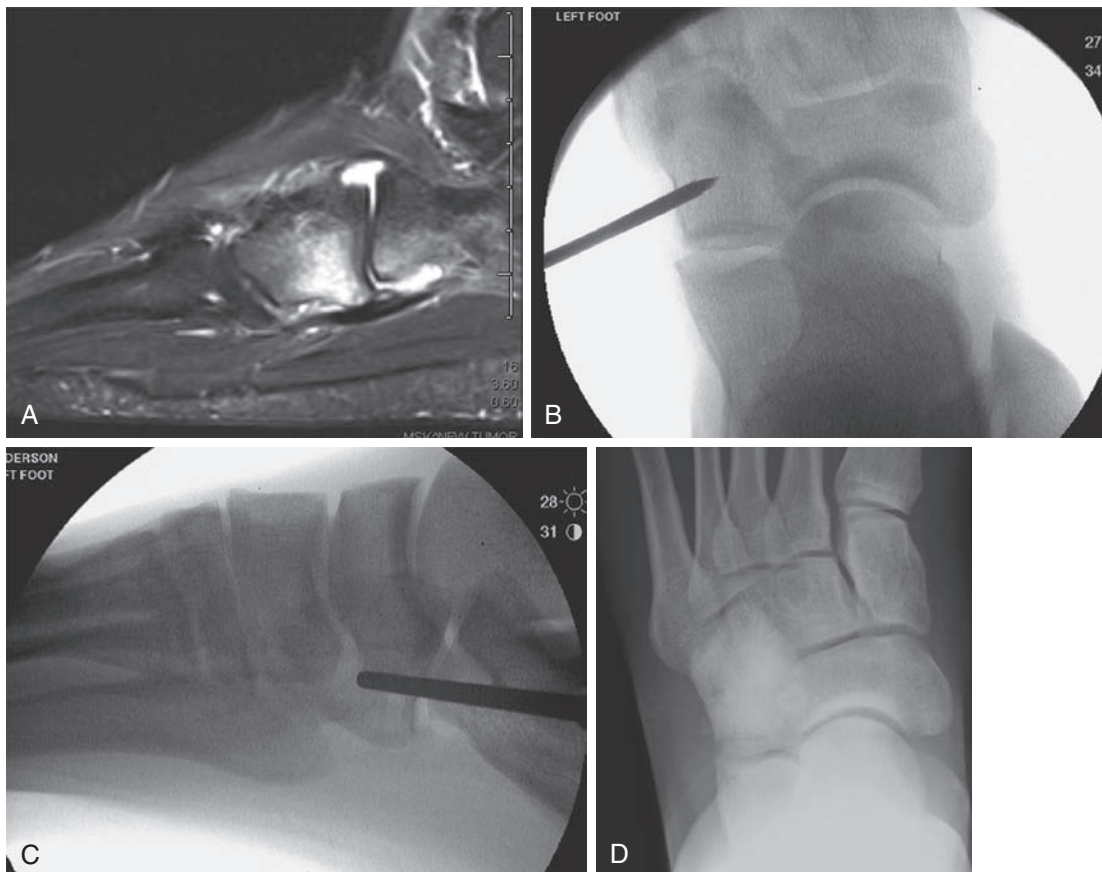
(A) Sagittal T2 MRI image of the foot of a 23-year-old athlete with chronic lateral midfoot pain. Bone marrow lesions are noted in the cuboid and consistent with a stress reaction. Intraoperative fluoroscopic (B) anterior-posterior and (C) lateral images noting placement of the cannulated trochar into the cuboid. (D) Standing anterior-posterior radiograph performed 4 weeks after injection of 1 cc of calcium phosphate into the cuboid.
